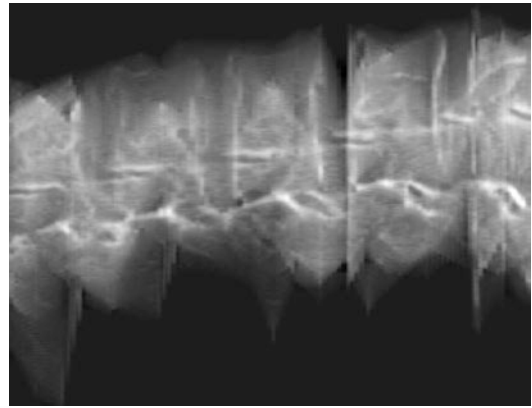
Example of a spine tracking DRR. The DRR is generated using only the CT image data within a segmented spine region, so that overlaying anatomical structures do not influence the tracking result
